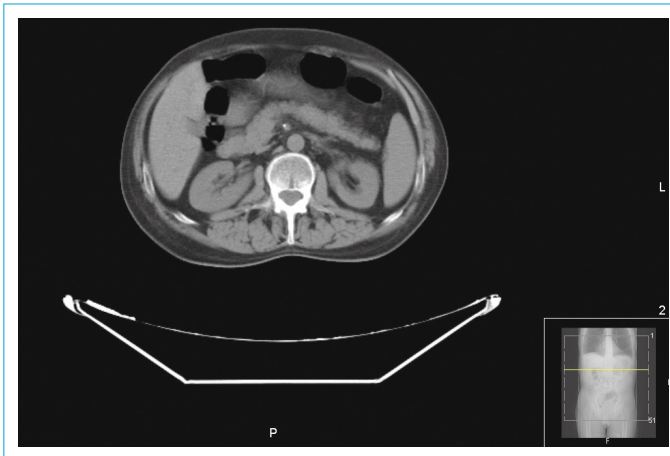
Non-contrast spiral computed tomography was performed to detect presence of a renal stone.
